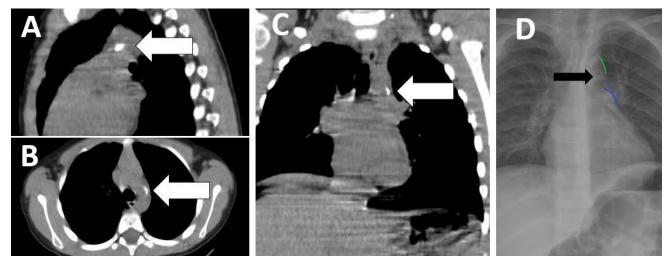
Demonstrating coarse-linear calcification of the ligamentum arteriosum on non-contrast thorax CT and chest radiography; In the sagittal (A), axial (B), and coronal (C) sections of the non-contrast thorax CT of a 3-year-and-11-month-old male patient, coarse-linear calcification (white arrows) is visible between the proximal descending aorta and the pulmonary artery. On the radiograph of the same patient (D), millimetric opacity (black arrow) is observed at the level of the 5th costochondral junction, between the aortic knob (green line) and pulmonary conus (blue line), and it corresponds to the calcification of the ligamentum arteriosum between the pulmonary artery and the aorta described in the CT images.
